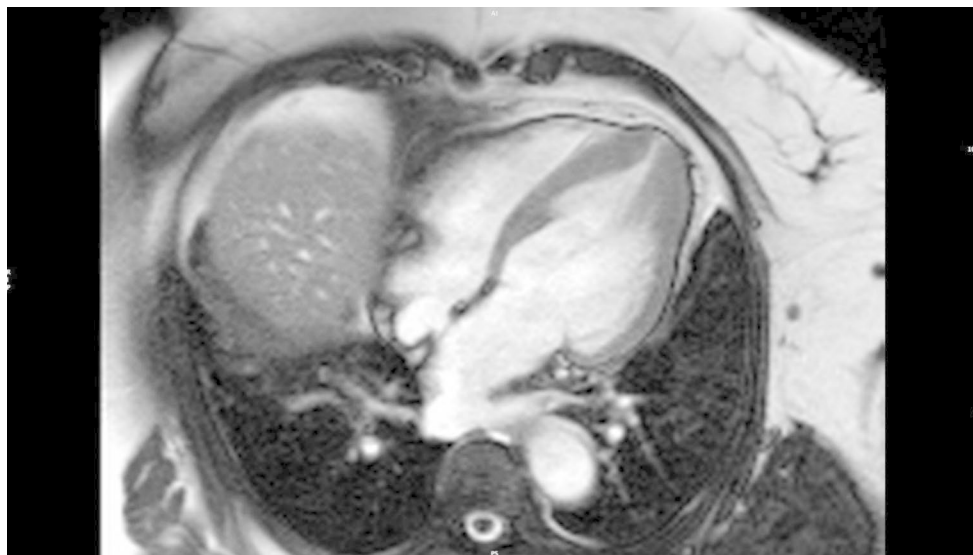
Cardiac magnetic resonance imaging of patient with apical hypertrophic cardiomyopathy, showing late gadolinium enhancement at the left ventricle apex
